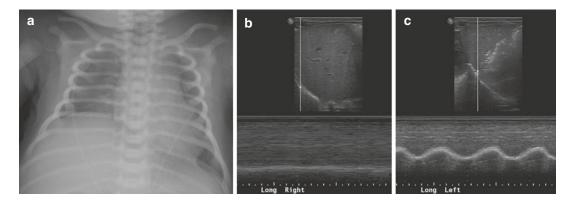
Diaphragmatic paralysis. (a) Chest radiograph shows asymmetric elevation of the right diaphragm following birth injury. (b) M-mode Doppler interrogation of the right diaphragm shows loss of the normal motion with a flat tracing. (c) M-mode Doppler interrogation of the left diaphragm shows normal waveform movement during the respiratory cycle
